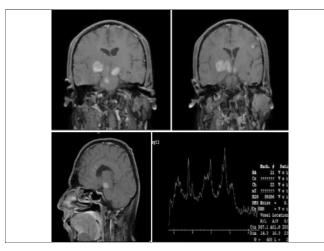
MRI brain and MRS. MRI brain showing multiple lesions in pons, left parietal region and corpus callosum. MRS showing raised lipid, lactate and choline peak and decreased NAA
